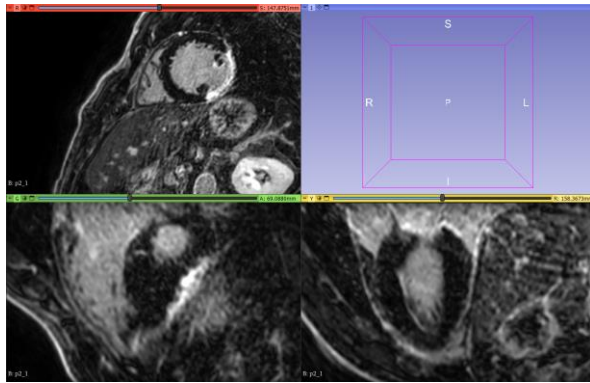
Image from 3DSlicer. Cardiac MRI from patient number 2. Top-left: axial plane, bottom-left: coronal plane, bottom-right: sagittal plane.
